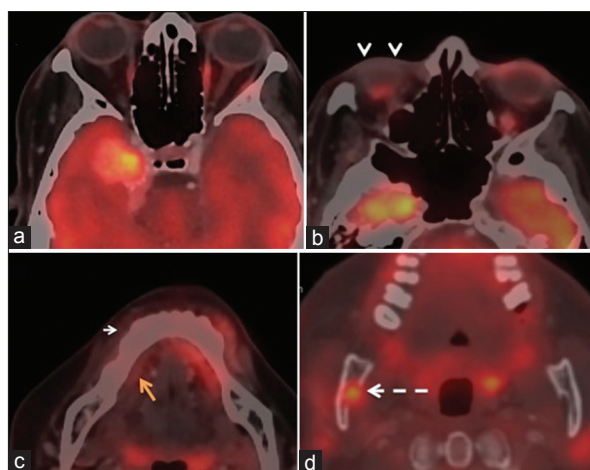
Indirect evidence of PNS on PET/CT seen as asymmetric decreased FDG uptake in the atrophied right lateral rectus muscle (a) and right orbicularis oculi/orbicularis oris muscle (b and c) which is supplied by VII nerve. Asymmetric decreased FDG uptake was also noted in the right mylohyoid muscle (c), secondary to PNS along inferior division of mandibular nerve with erosion of the right mandibular foramen [dashed white arrow, (d)]
